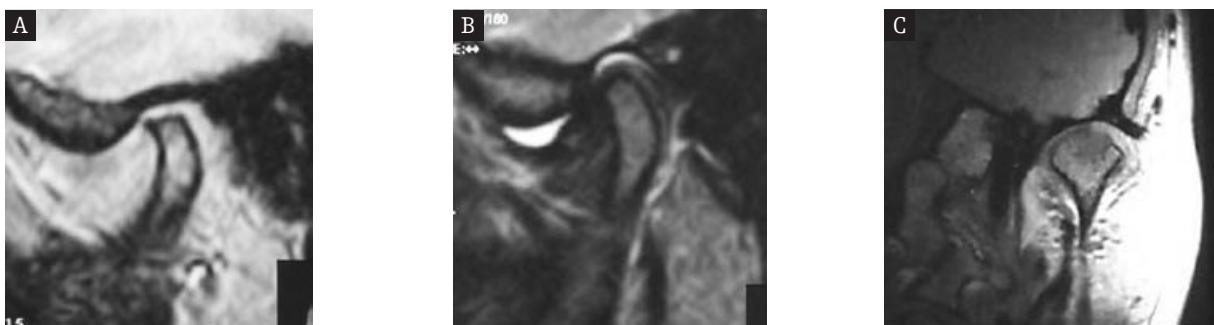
MRI of the TMJ. Locked anterior disc displacement. Flattening of mandible head, osteophytes (A). Exudate in the articular cavity (B). Myelodegenerative changes (C). IV° in Wilkes score.
